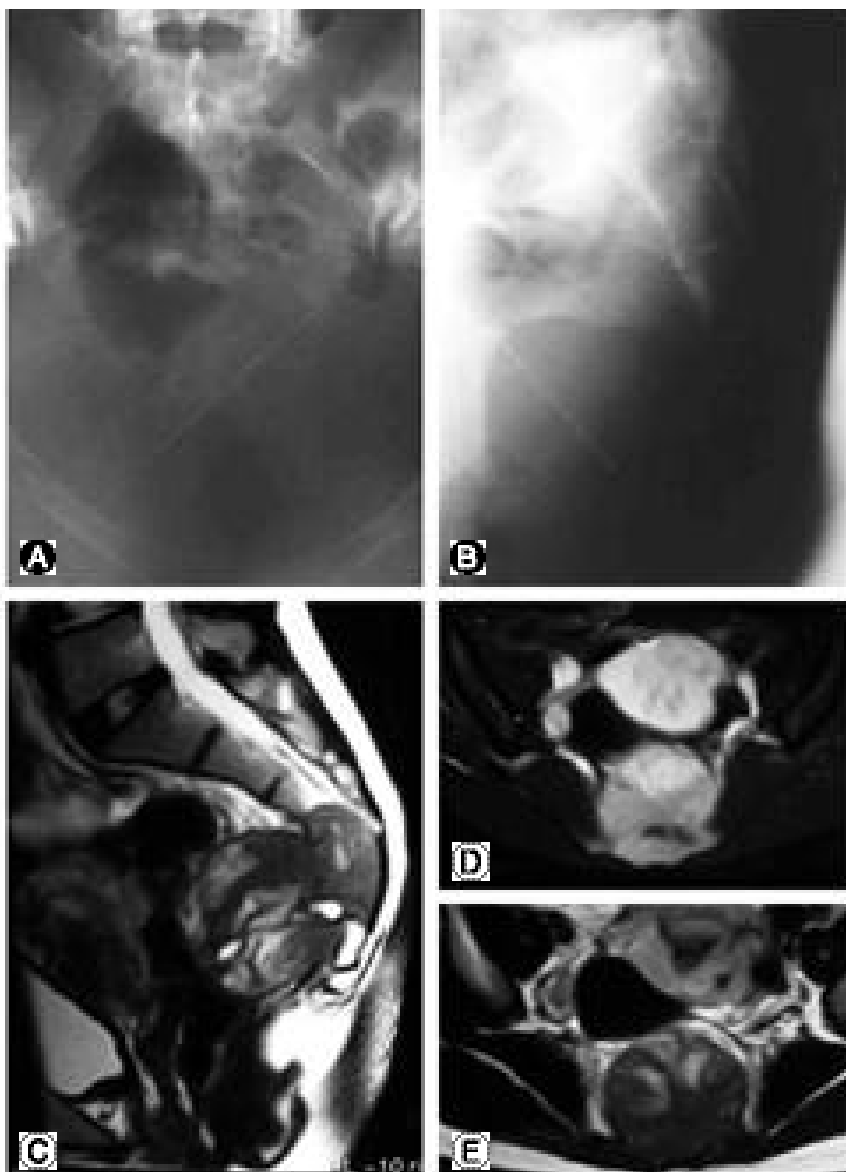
Preoperative radiographic studies of case 2. AP (A) and lateral (B) plain roentgenographs show radiolucency at the lower half of sacrum. Sagittal T-2 weighted MRI (C), axial T-1 weighted MRI (D), and axial T-2 weighted MRI (E) show the that the tumor mass is arising from lower sacrum and expanding into the pelvic cavity.
